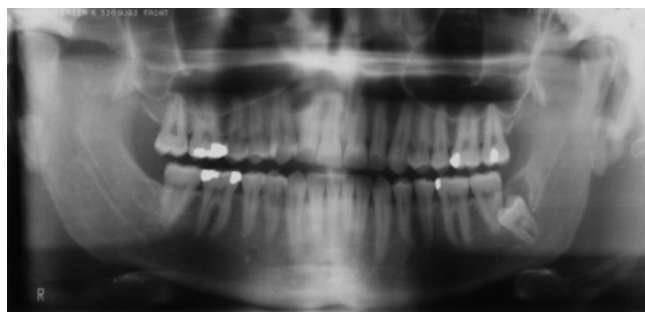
Initial panoramic radiograph. Note the deep impaction of tooth #38.
